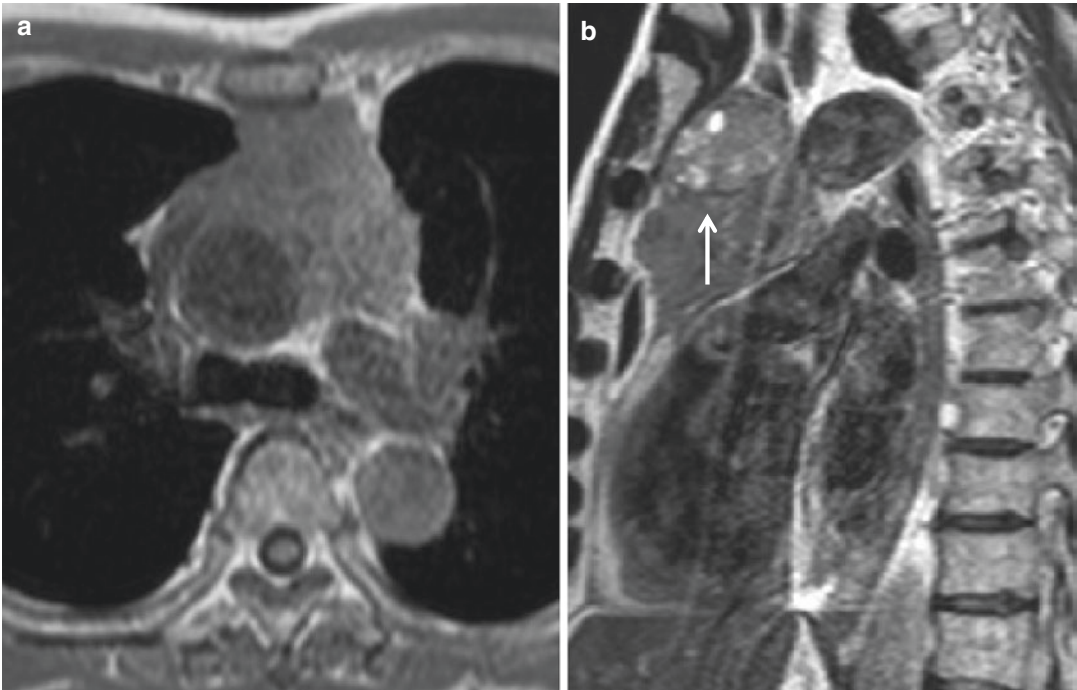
Invasive thymoma. (a) T1-weighted axial and (b) T2-weighted coronal MR images show an irregular mass in the anterior mediastinum, surrounding the great vessel.
